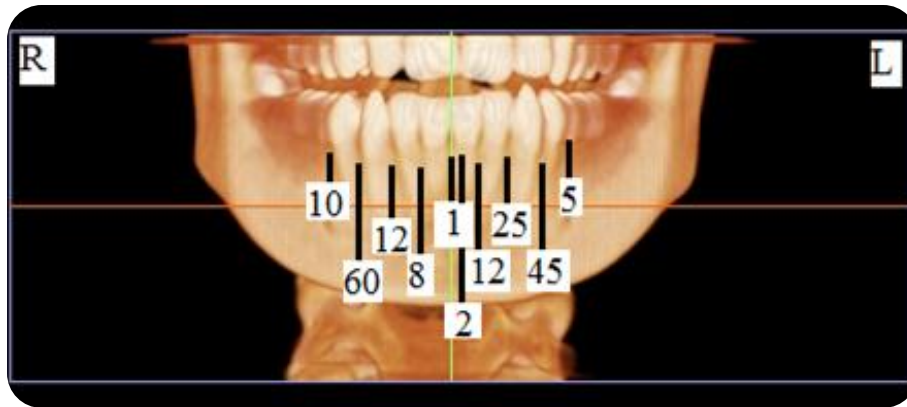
The frequency of the location of Lateral Lingual Vascular Canals ranging between mandibular teeth (LLVCsr) when there was one canal on one or both sides (Images obtained with i-CAT® Model 17-19; CBCT Imaging Unit: InVivoDental5 Version 5.2 Anatomage, software): Dentomaxillofacial Radiology Department; Faculty of Dentistry, University of Yeditepe.
